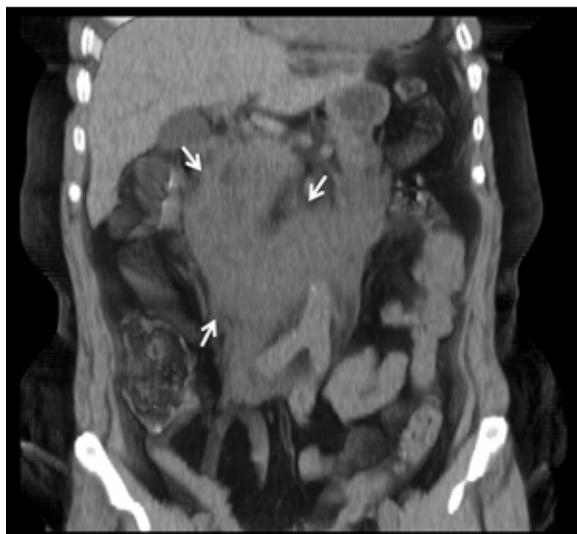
Coronal reformatted CT image demonstrates duodenal thickening due to inflammation.
